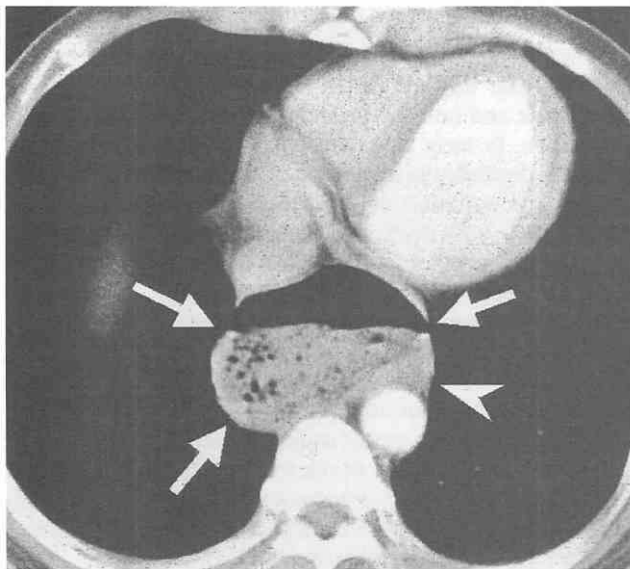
Epiphrenic diverticulum. CT scan demonstrates a thin-walled, air-fluid-filled structure (arrows) in the distal esophagus. The esophageal wall (arrowhead) is laterally displaced.
